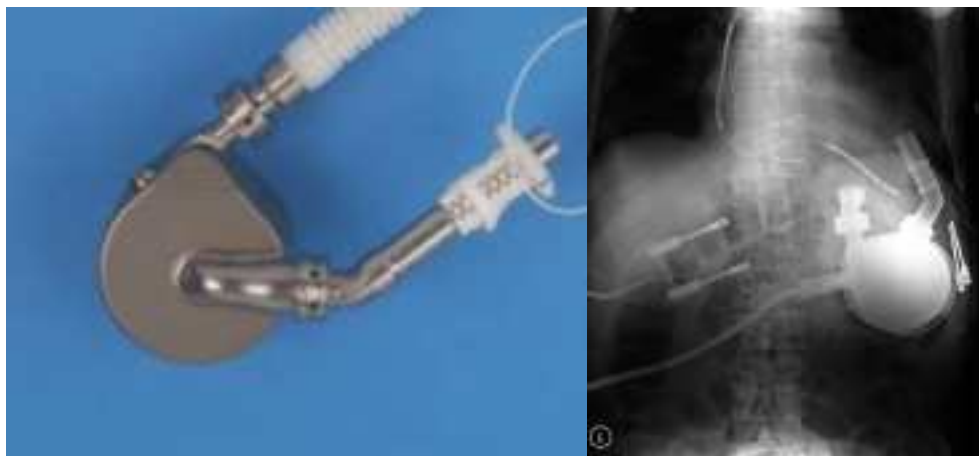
Picture and x-ray from DuraHeart™.
